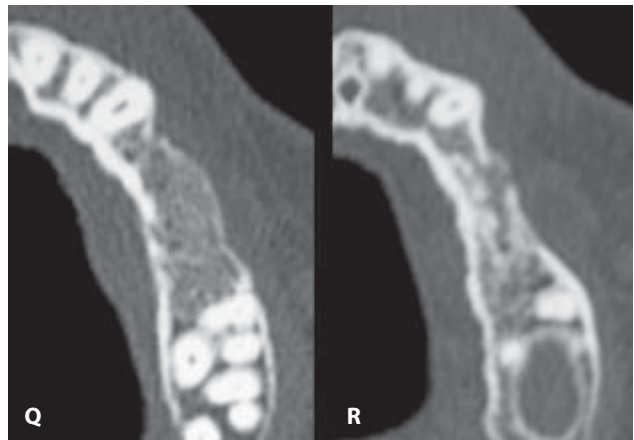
Two different CT radiographic pictures showing the improvement of the buccal bone contour.
